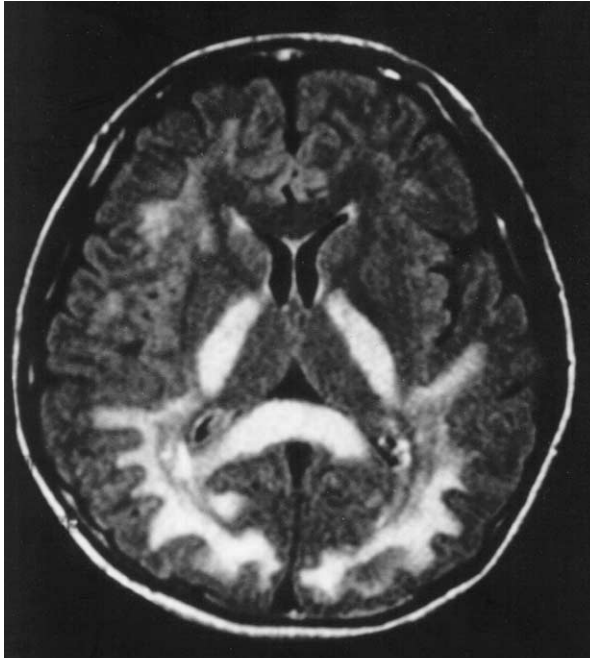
Modified T₂-Weighted Spin-Echo MRI Scan of the Brain in Patient 1.
